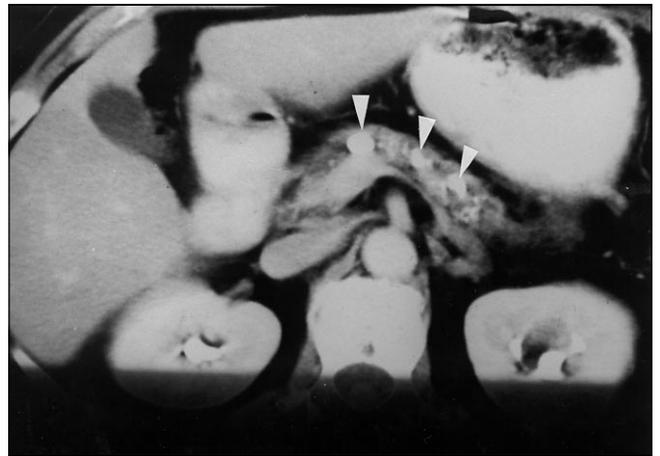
Computed tomographic scan showing multiple ductal stones up to 12 mm in diameter (arrows)
